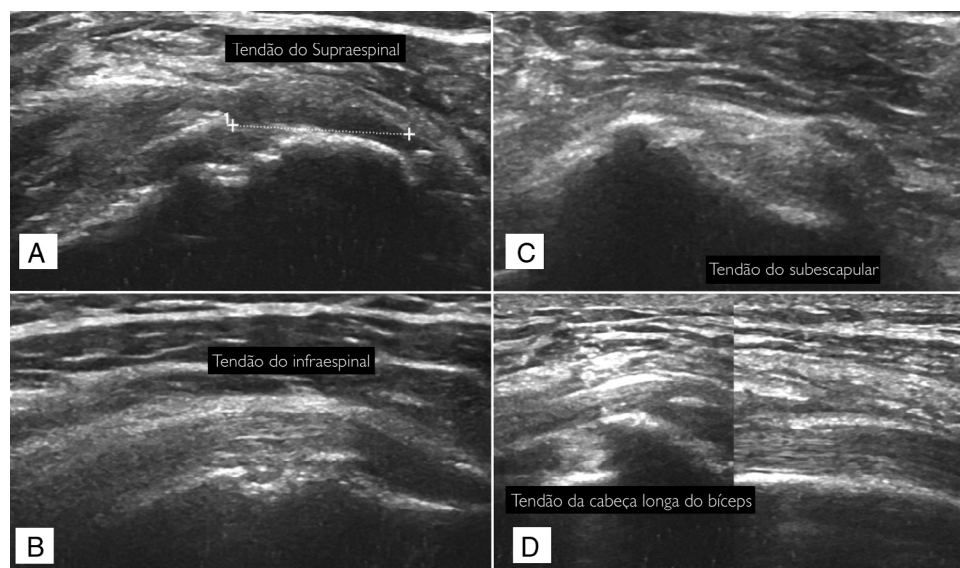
Ultrasonographic evaluation of the rotator cuff. (A) Supraspinatus tendon rupture; (B) infraspinatus tendon; (C) subscapular tendon; (D) long head of the biceps tendon.
